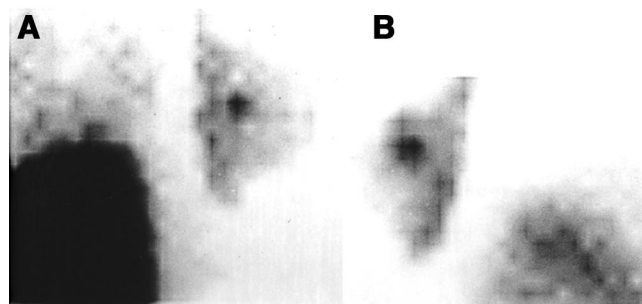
P-¹²³I-MBA scintigraphy in 2 patients with primary breast cancer of invasive ductal type. Tumor was localized in laterosuperior quadrant of right breast (A) and left breast (B).
